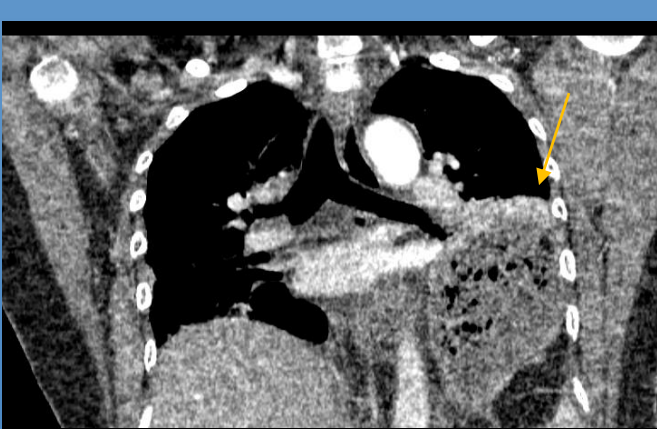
CT imaging with yellow arrow showing herniation of stomach into thoracic cavity.
